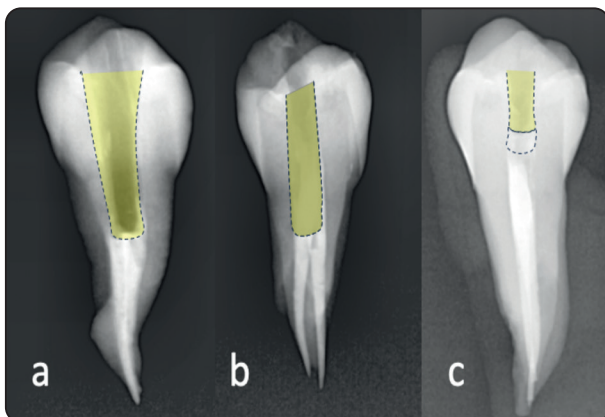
Radiographic evaluation for three obturated premolars with the three endodontic access cavity designs (highlighted) [(a)TEC, (b)CEC, (c)TUS]
